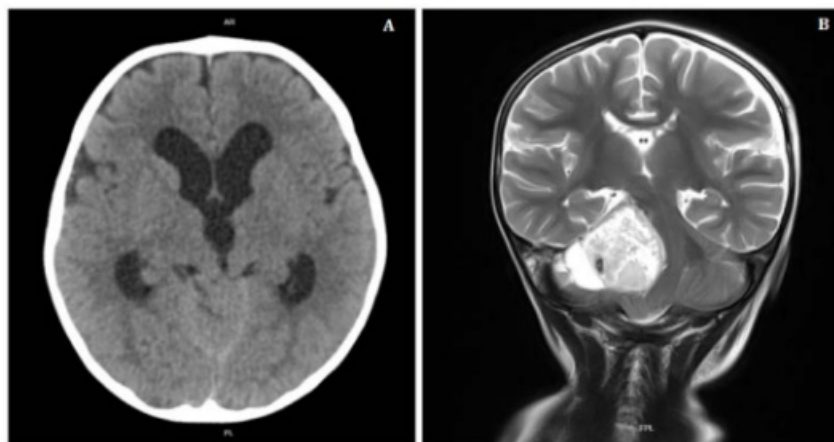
Preoperative neuroimaging of the pediatric medulloblastoma case. Panel A shows the axial image and Panel B the coronal MRI view, demonstrating a right posterior fossa lesion with marked mass effect, brainstem displacement, and fourth-ventricle compression
